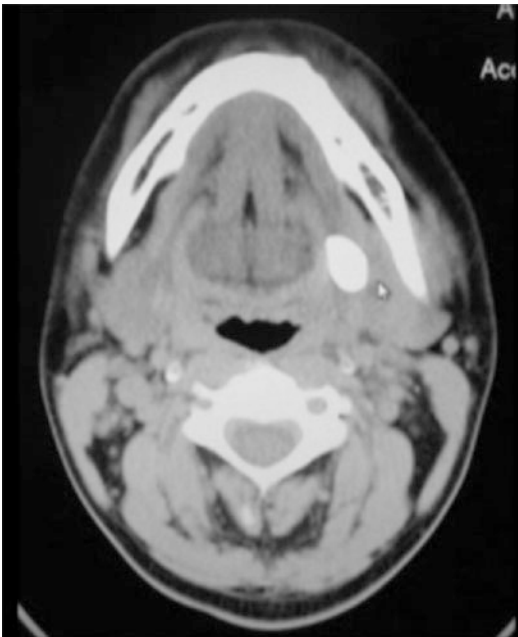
Axial CT scan showing left submandibular hilar megalith (20 mm in maximum dimension)
